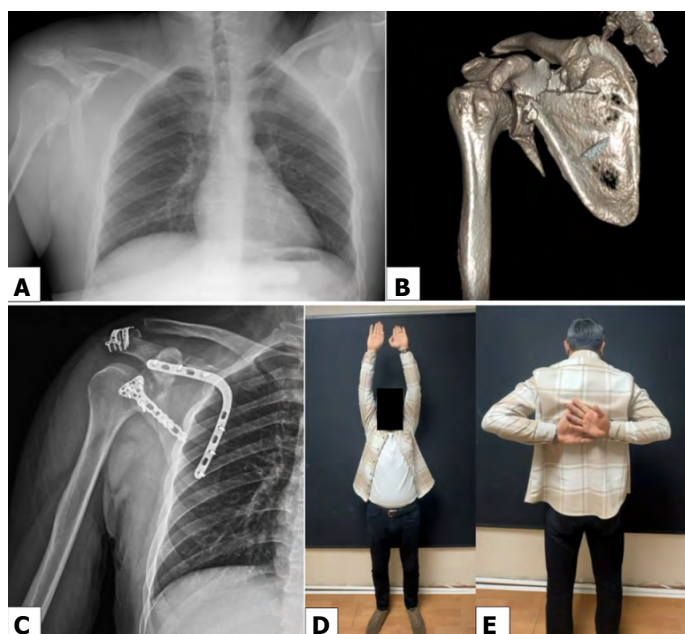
Representative case of a patient with a displaced scapular fracture treated with open reduction and internal fixation using the modified Judet approach. (A) Pre-operative radiograph demonstrating fracture displacement. (B) Three-dimensional computed tomography reconstruction showing fracture configuration and glenoid involvement. (C) Post-operative radiograph demonstrating anatomical reduction and stable fixation. (D) Clinical photograph demonstrating satisfactory forward elevation. (E) Clinical photograph demonstrating internal rotation at final follow-up.
